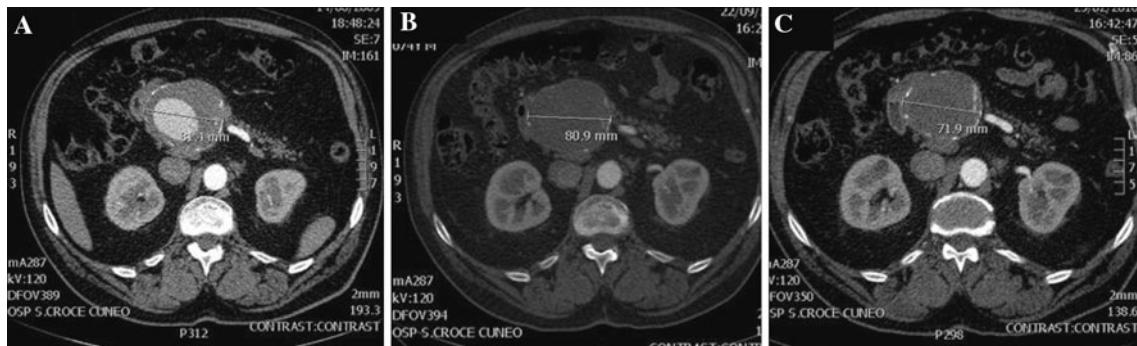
Shrinking of the aneurysm. Initial CTA (A), follow-up CTA at 1 month (B), and follow-up CTA at 6 months (C) show progressive decrease of the aneurysm sac from 81.4 to 71.9 mm
